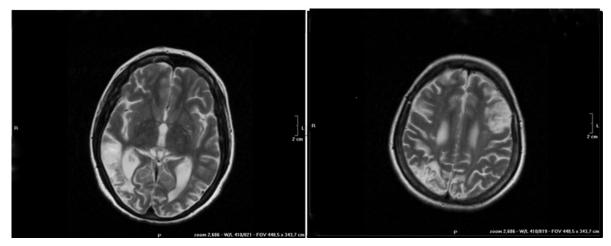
T2-wighted Brain MRI shows presence of brigth mulftifocal foci and encephalomalacia areas in right parietal-occipital lobe (A) and left parietal lobe (B).
